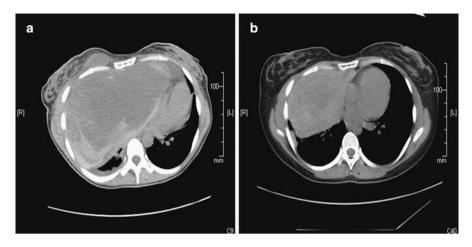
Noncontrast CT images of a 35-year-old female patient with aggressive chest wall desmoid with cardiovascular collapse who responded to sorafenib. (a) Pretreatment. (b) 28 months after starting sorafenib
